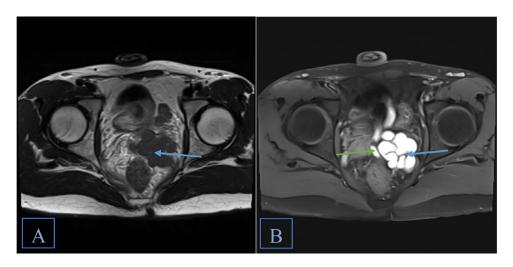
MRI axial T2 (A) and T1-fat suppression (B) weighted images showing the cystic dilatation of left seminal vesicle (blue arrow) with a dilated ejaculatory duct (green arrow) which elicit hypointense signal on T2-weighted imaging (A) and hyperintense signal on T1-fat suppression (B), suggestive of hemorrhagic/proteinaceous contents.
